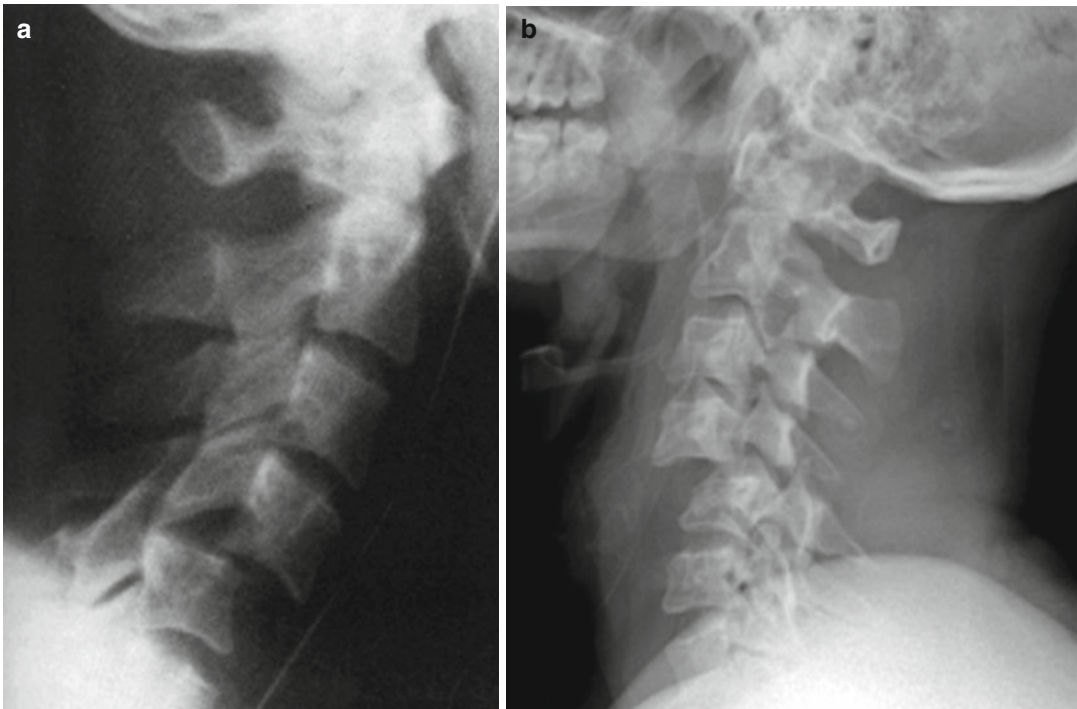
(a, b) Plain X-ray showing C4–C5 bilateral locked facets
